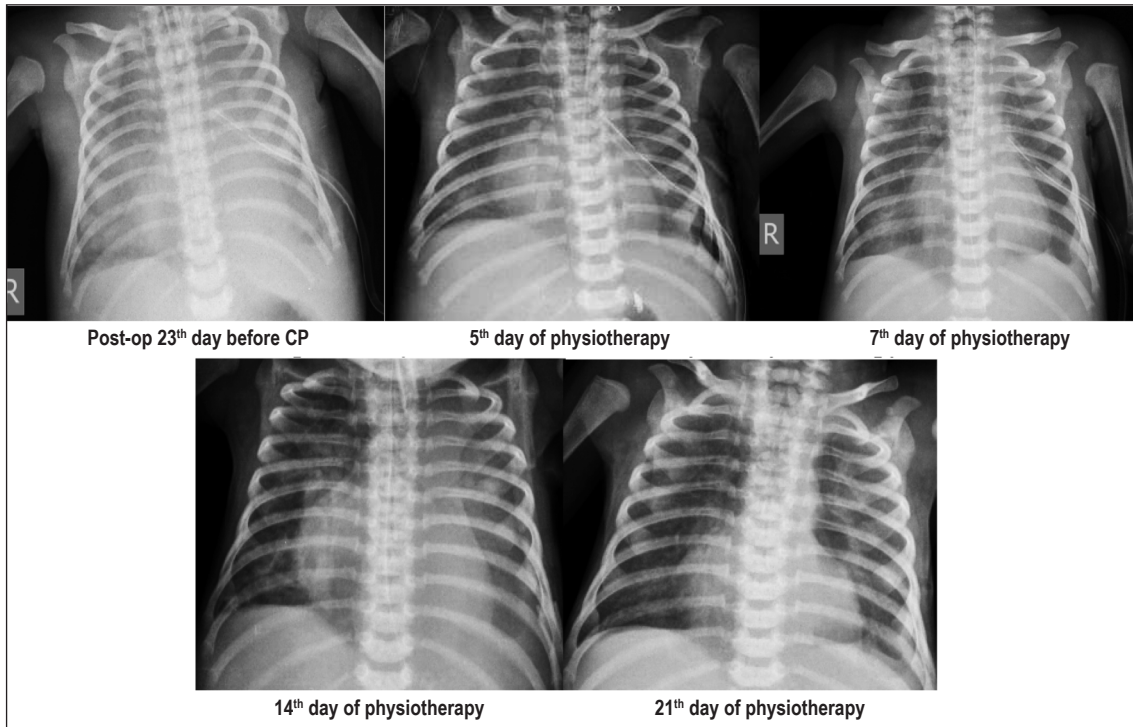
AP chest X-rays before and after chest physiotherapy (CP).
